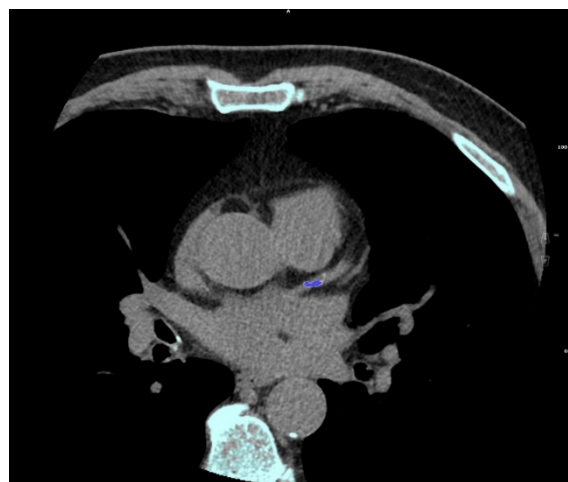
The quantification of CACS can be determined using multidetector computed tomography. Agatston score is used to measure the CAC score. Coronary calcification lesions are shown by the blue color area.
